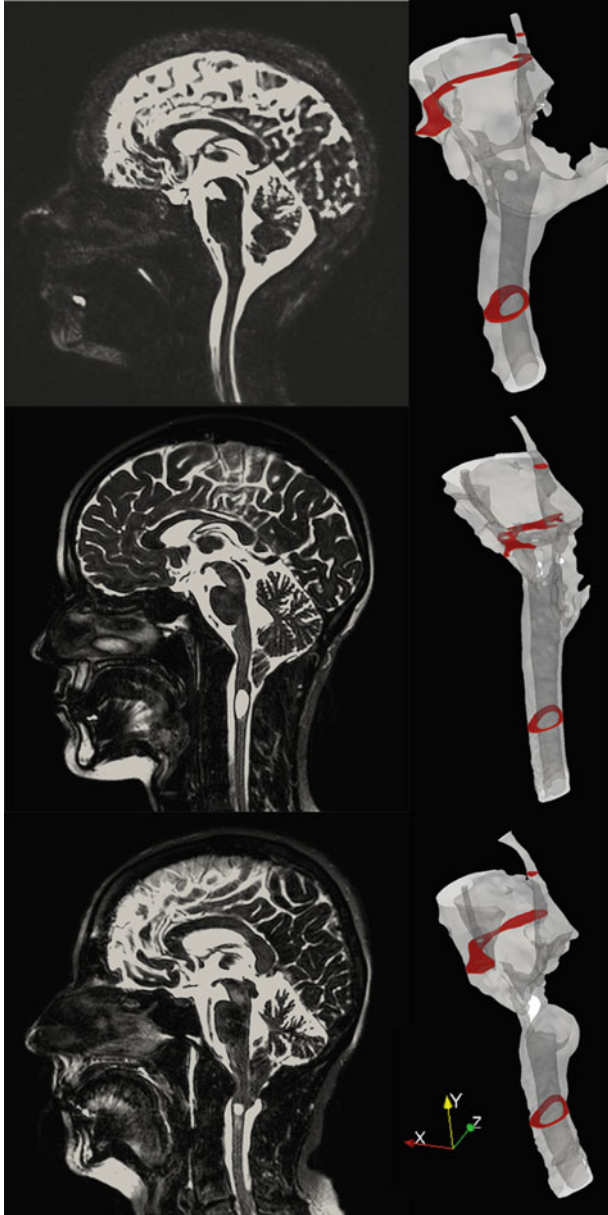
Segmentation of spinal SAS from MR images using VMTK. Left: Heavily fluid-weighted MRI (3D constructive interference in steady state, CISS) of one control subject and two Chiari I patients, females of 40, 26 and 63 years of age, respectively. Right: 3D reconstructed surface models. (Reproduced with permission from [25])
